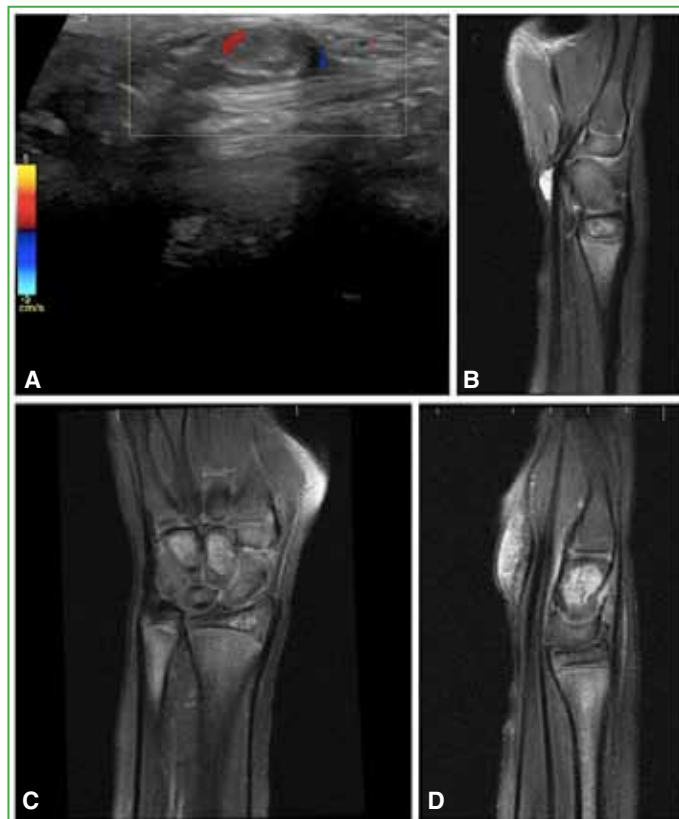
A. Anechoic ultrasound image of the tendon structure. B. Sagittal MRI PD FSE FS showing a hyperintense synovial cyst. C and D. Coronal and sagittal MRI PD FSE FS with bone lesion in the capitate bone, without associated bone lesions.
